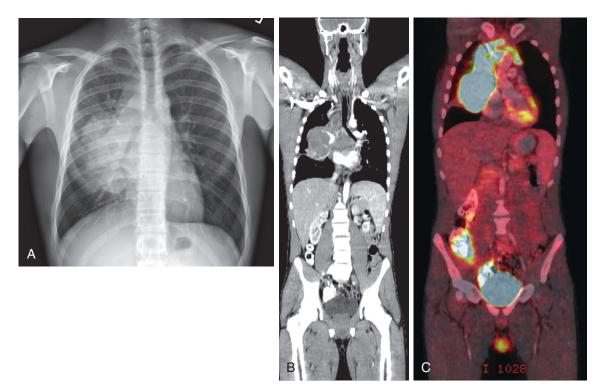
Hodgkin lymphoma. A, Chest x-ray demonstrating a large anterior mediastinal mass in a teenage male presenting with Hodgkin lymphoma. B, Chest computed tomography (CT) demonstrating the mediastinal mass. C, ¹⁸F-labeled 2-fluoro-2-deoxyglucose positron emission tomography (FDG PET) demonstrating the metabolically active tissue of the malignancy as intensely bright areas relative to normal tissues.
